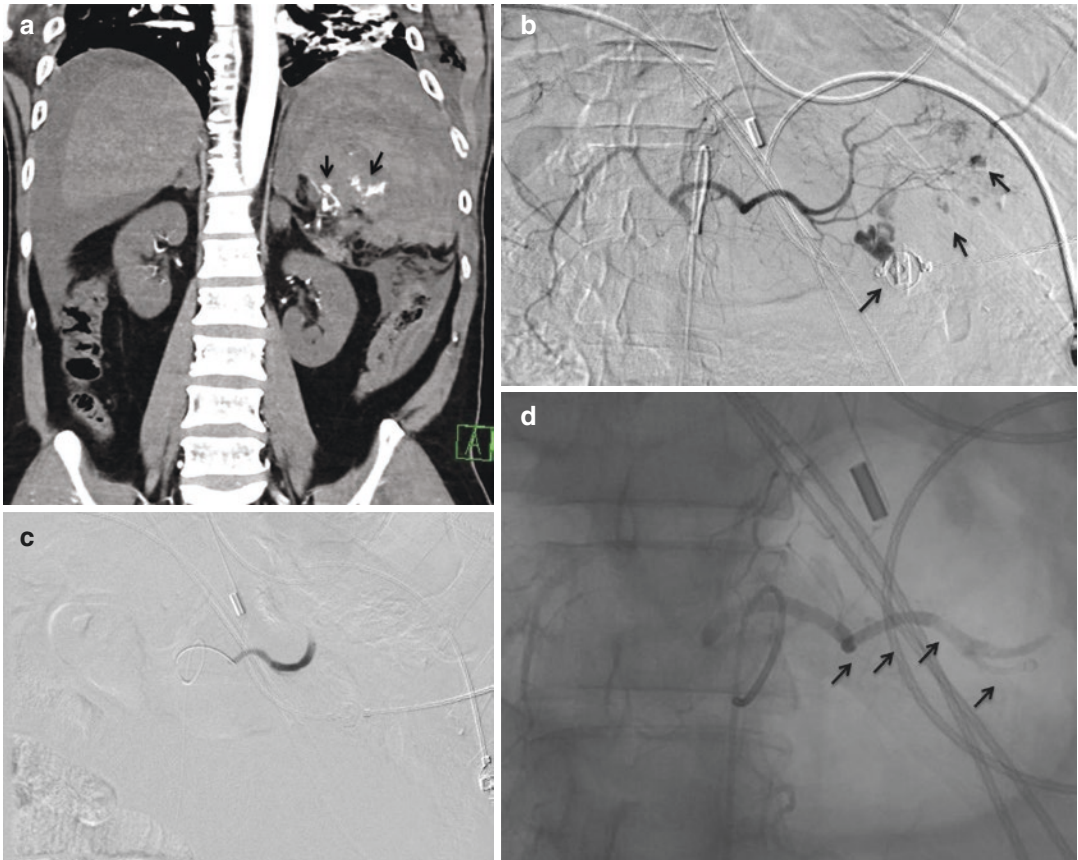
Proximal and distal embolization in a patient with grade 5 splenic injury (a) Coronal arterial phase CT showing shattered spleen with multifocal extravasation (arrows). (b) Splenic artery DSA showing multifocal extravasation (arrows) from splenic arterial branches. (c)
